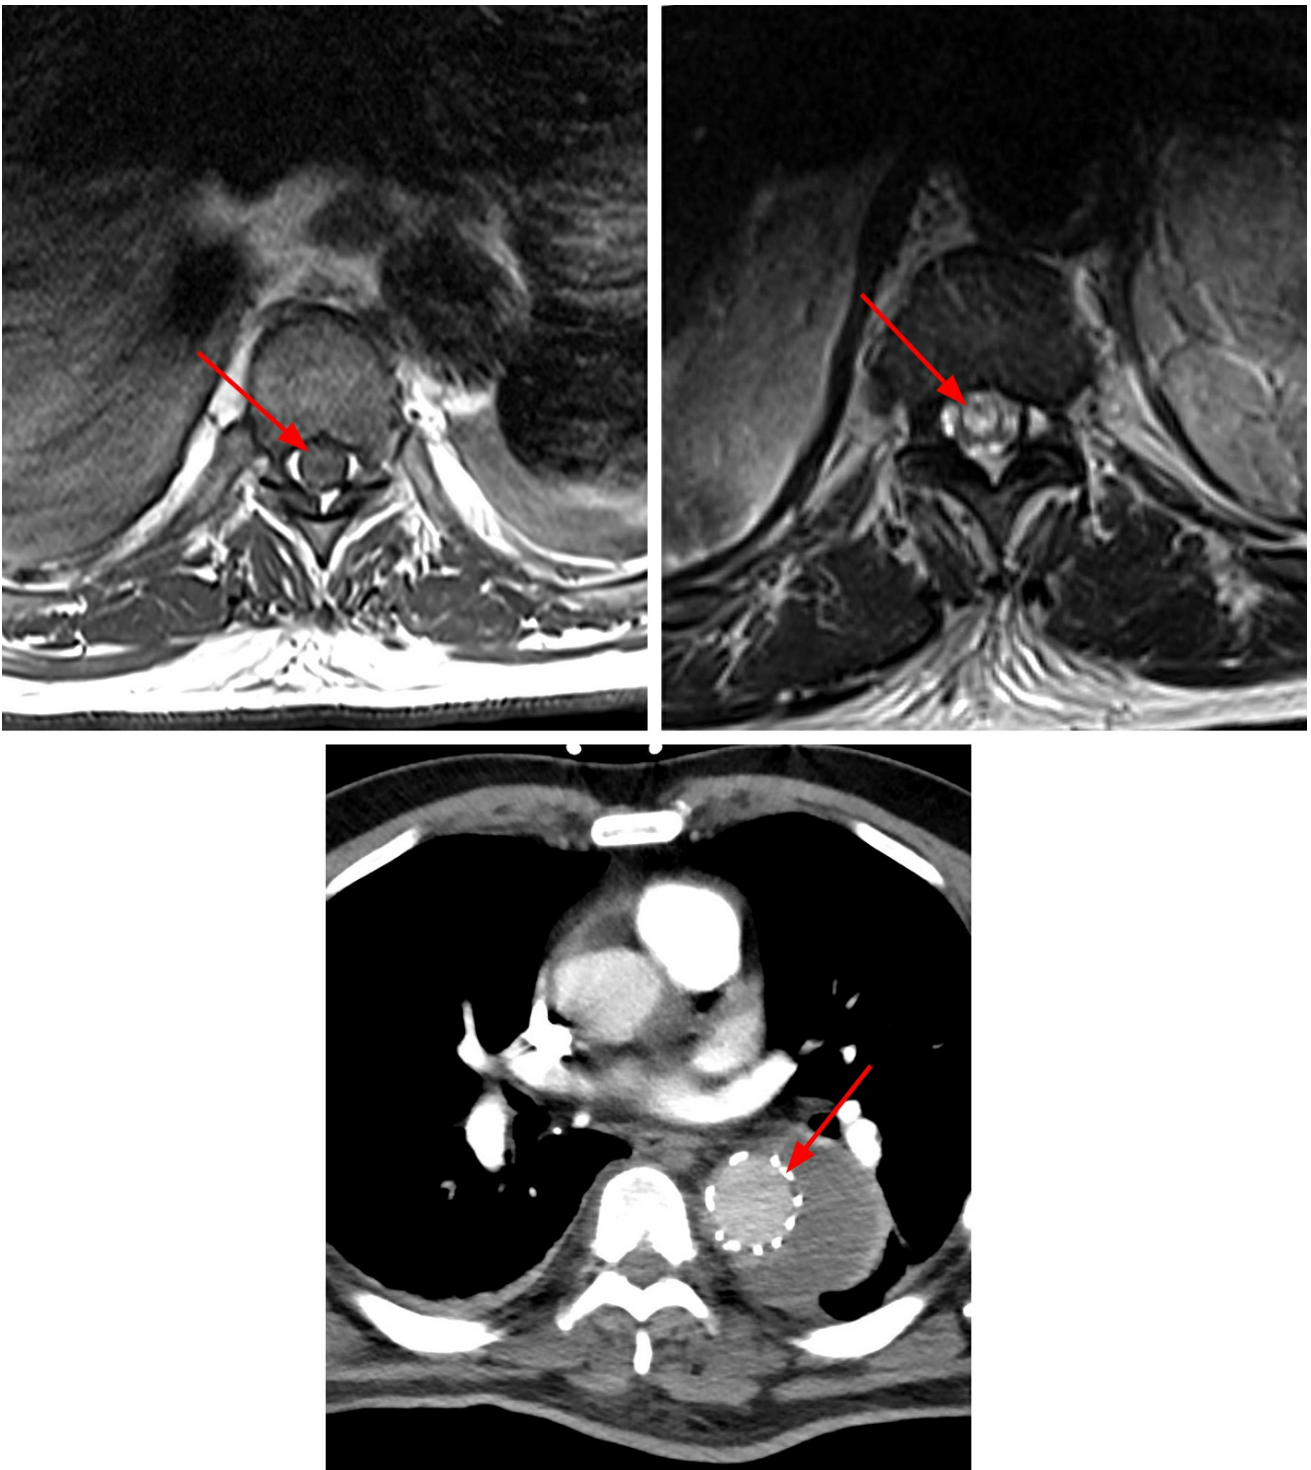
Low signal T1 spinal cord signal (Top Row Left) - difficult to appreciate- and owl's eye appearance of hyperintensity in the central spinal cord on T2-weighted image (Top Row Right). The patient had recently undergone aortic stent graft placement for aortic aneurysm, visible on CT angiogram (Bottom Row).
